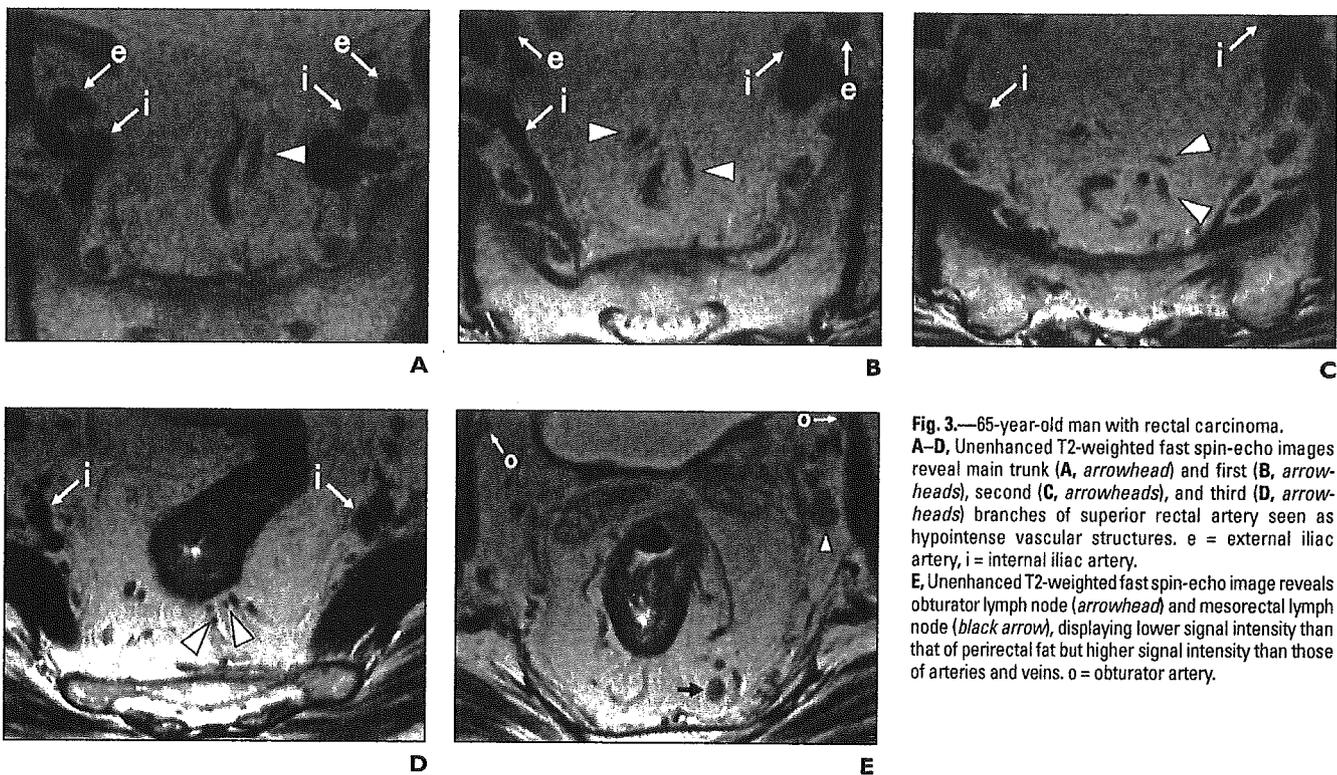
65-year-old man with rectal carcinoma. A–D, Unenhanced T2-weighted fast spin-echo images reveal main trunk (A, arrowhead) and first (B, arrowheads), second (C, arrowheads), and third (D, arrowheads) branches of superior rectal artery seen as hypointense vascular structures. e = external iliac artery, i = internal iliac artery. E, Unenhanced T2-weighted fast spin-echo image reveals obturator lymph node (arrowhead) and mesorectal lymph node (black arrow), displaying lower signal intensity than that of perirectal fat but higher signal intensity than those of arteries and veins. o = obturator artery.
